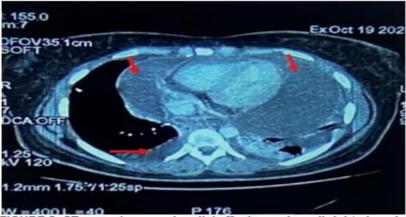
CT scan shows pericardial effusion and small right pleural effusion.
